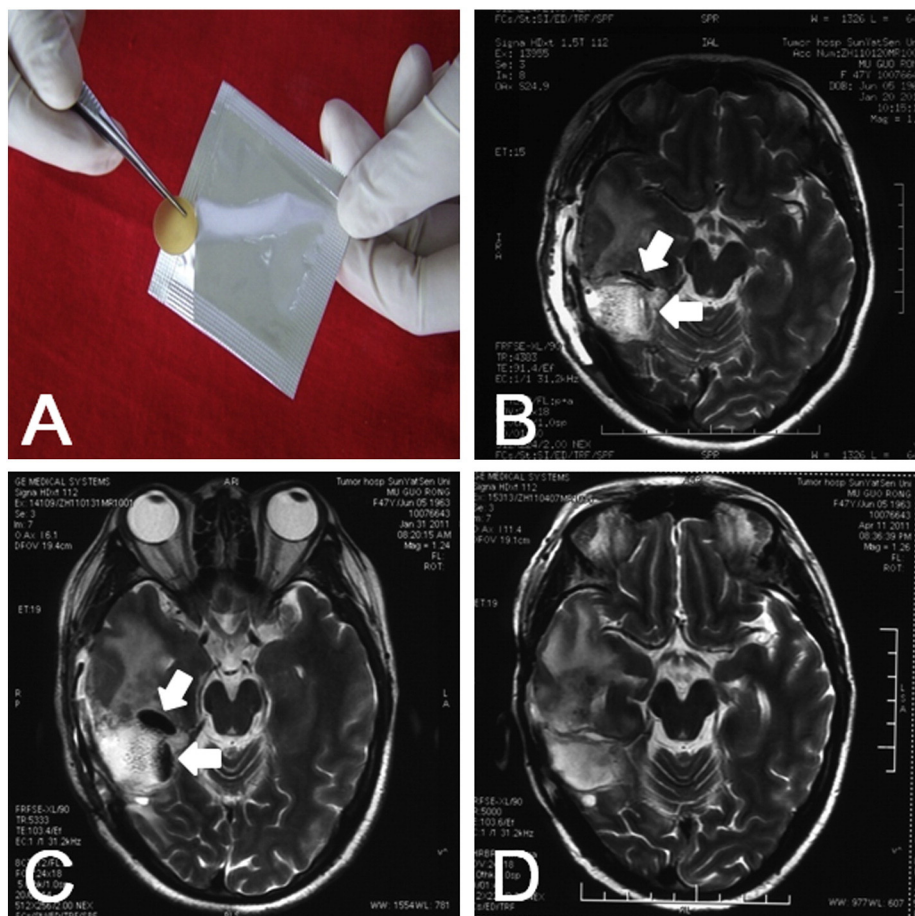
Physical and imaging characteristics of BCNU-loaded PLGA implants. The BCNU-loaded PLGA implant is a pale yellow disk, with a diameter of 14 mm and a thickness of 1 mm (A). The implants presented as hypointense objects on T2-weighted MR images (Day 3 after implantation, arrows in B). The volume of the implants expanded gradually (Day 14 after implantation, arrows in C). The implants were undetectable on MRI 3 months after implantation (D).
